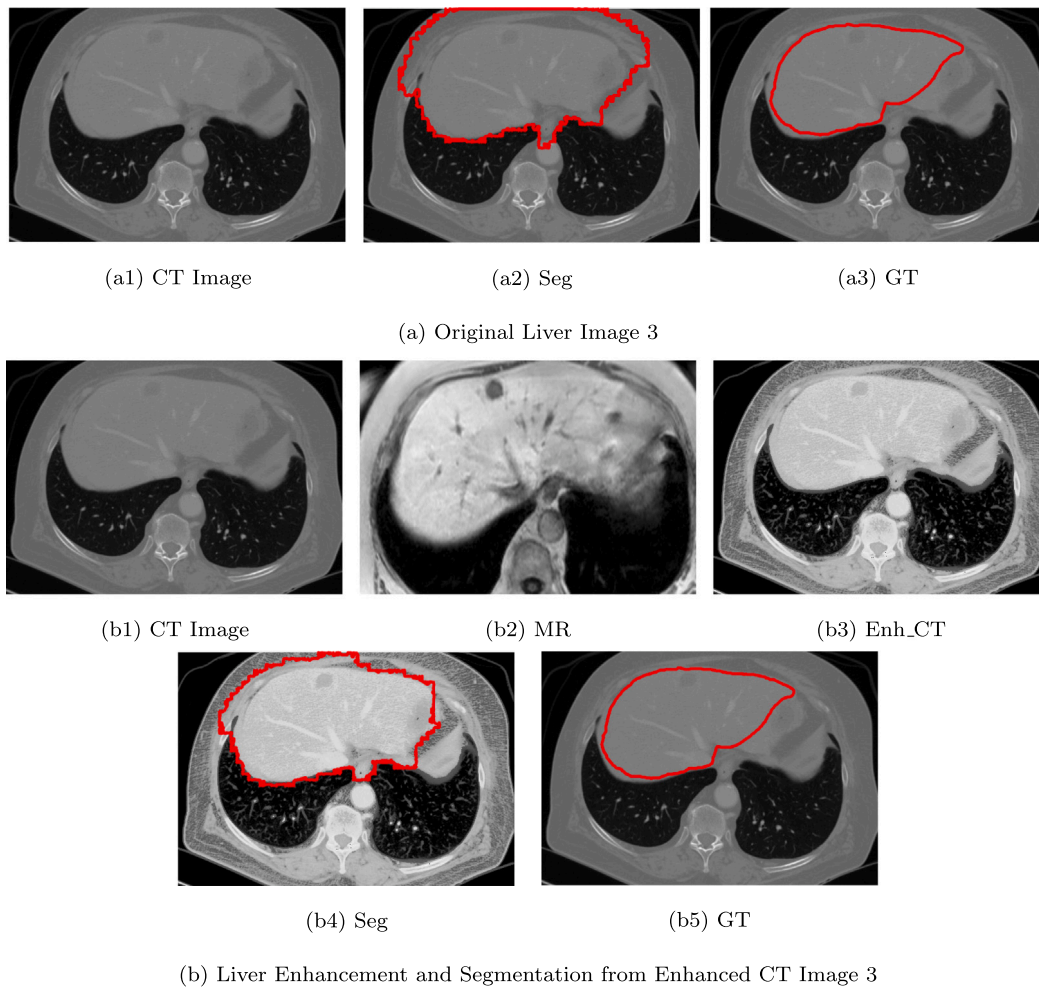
Liver segmentation from original and enhanced CT image 3.
